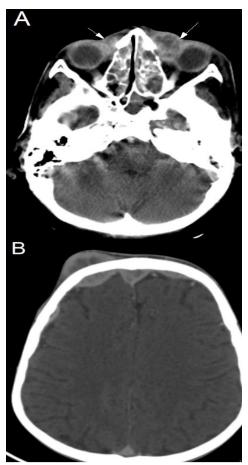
A: Axial computed tomography slide shows bilateral tissue formations of the internal canthus related to secondary locations.
